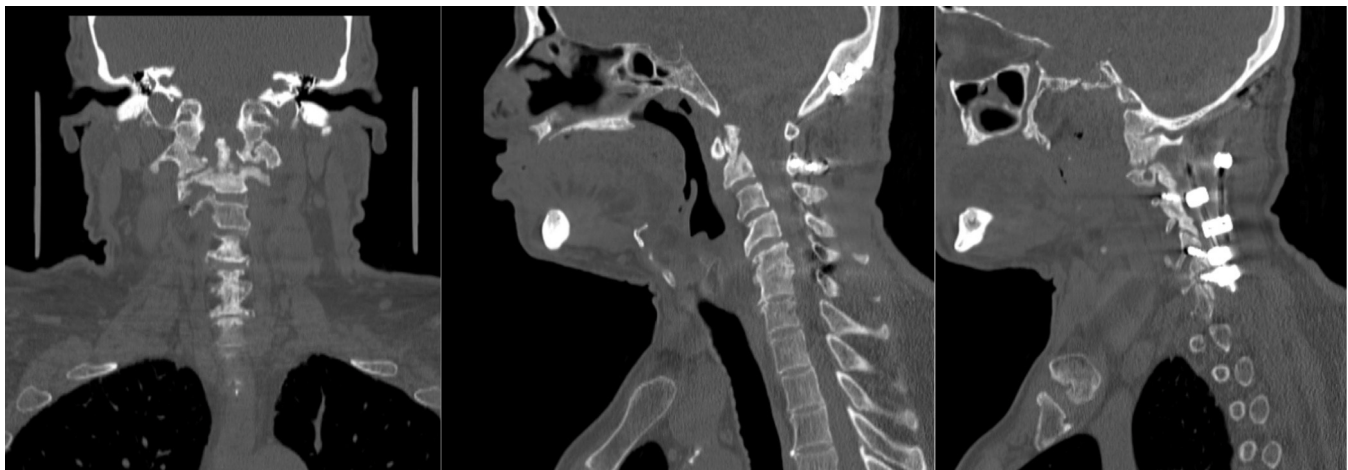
CT scan showed reformation of the odontoid process, bone healing of the C1 and C2 and fusion.
